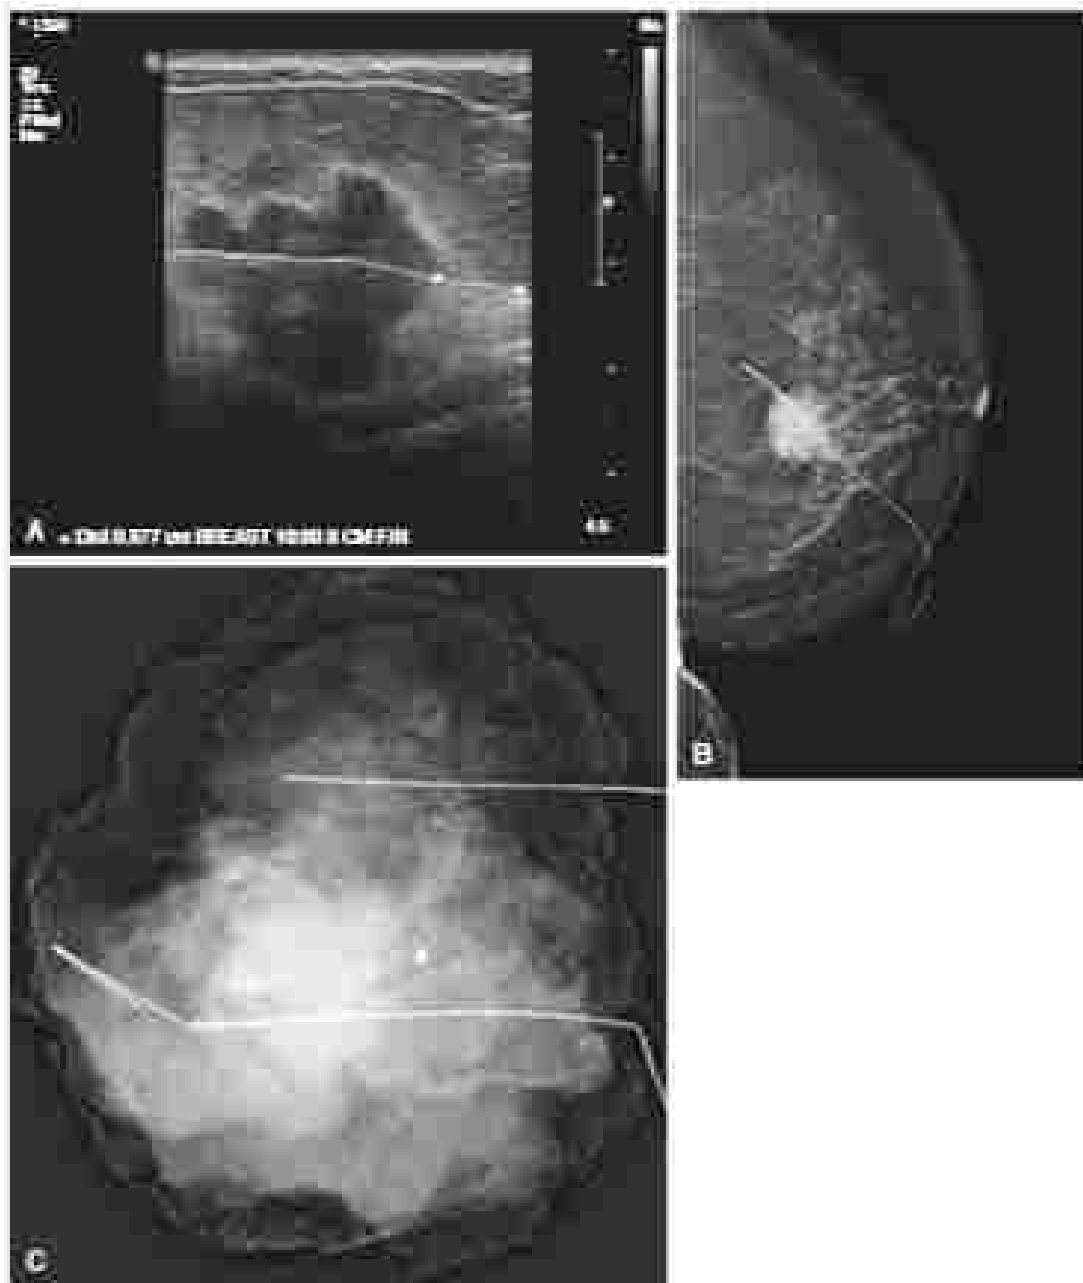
Wide local excision (A) A parasternal wire with a parasternal wire 1 cm from the DCIS. (B) parasternal wire with a 2-cm margin. (C) parasternal wire with a 3-cm margin. (A) parasternal wire with a 1-cm margin. (B) parasternal wire with a 2-cm margin. (C) parasternal wire with a 3-cm margin.
